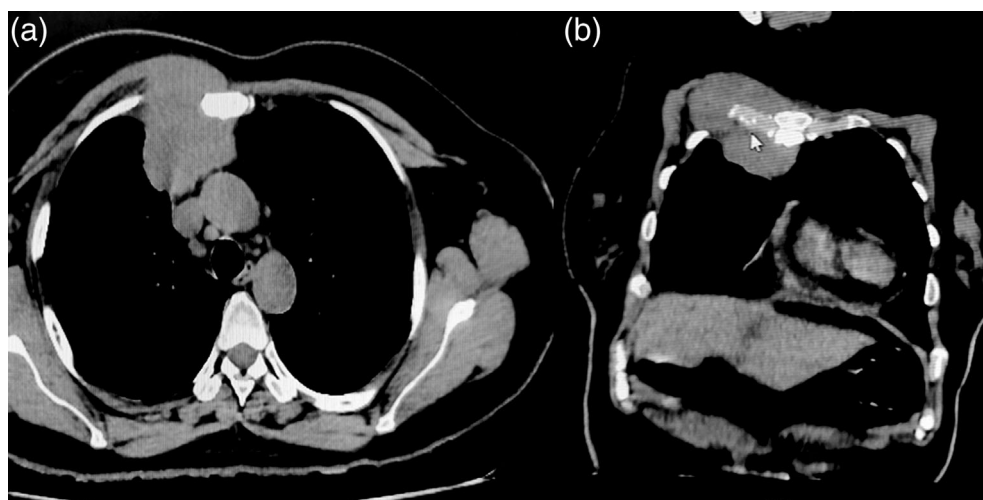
Initial noncontrast computed tomography (CT) scan. (a) The axial view revealed a tumor arising from the intercostal soft tissues with expansion to the anterior mediastinum. (b) The coronal view revealed foci of osseous lysis of the right first costal arch (white arrow). Simple CT scan (a) axial projection and (b) coronal projection.
